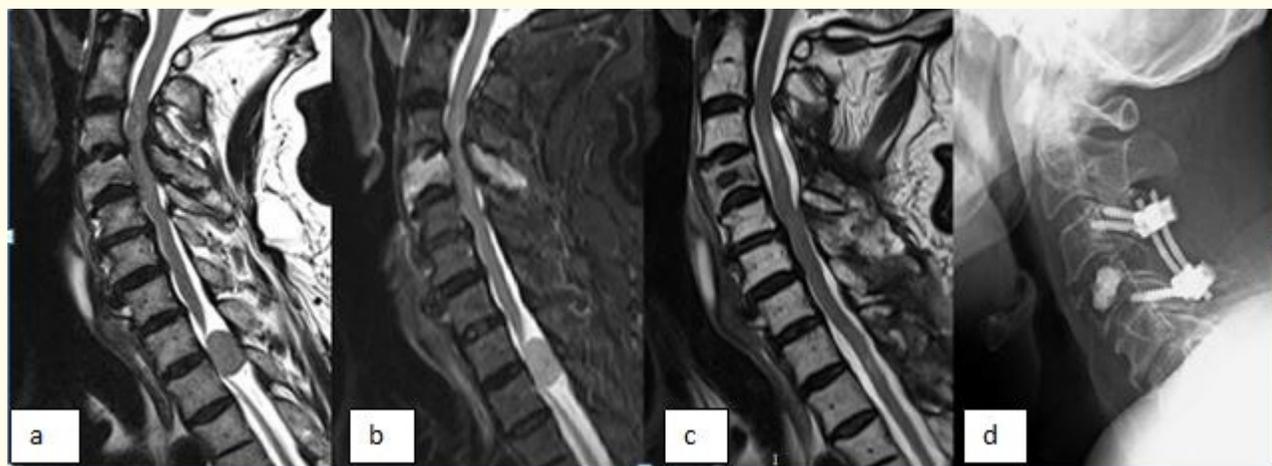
Cervical stenosis, lytic infiltration in C4 vertebrae and smooth shaped intradural mass in upper thoracic region is seen in different sagittal T2 sequence. (a,b) Postoperative sagittal T2 image shows the canal decompression at cervical region, mass excision in thoracic region and acrylic application. (c) Postoperative X-ray shows lateral mass screw application and bone reconstruction in C4 (d).
